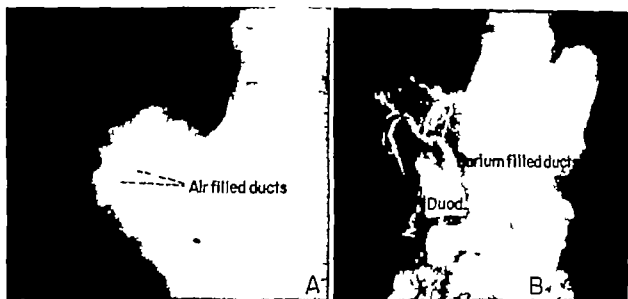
Roentgenogram of a spontaneous cholecystoduodenal fistula.
